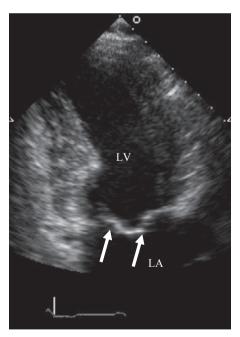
Panel A: Post-operative two-dimensional echocardiogram from the apical three chamber long-axis view. The site of the inserted pericardial patch is clearly seen (arrow). Residual systolic anterior motion is absent.
